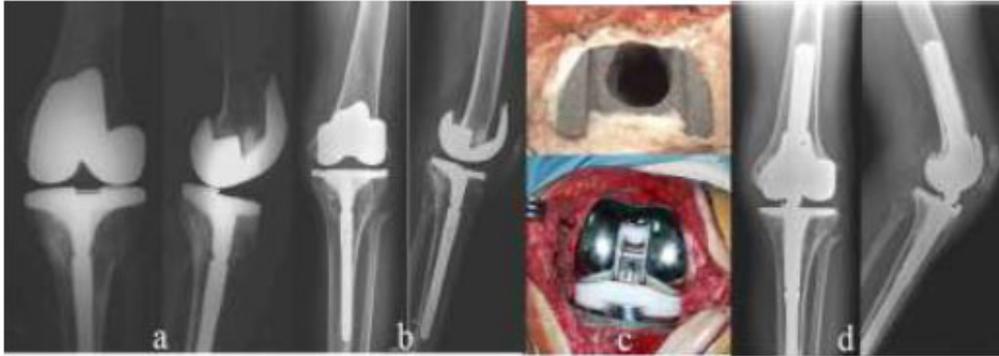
Radiologic history of the case presented in Fig. (2). Primary TKA in a 42 years-old haemophilic patient with high-titre inhibitors (a) . Four years after TKA, aseptic loosening with mechanical failure of the femoral component and in the posterior aspect of the tibial baseplate induced by recurrent bleedings (b) . The availability of a modern modular knee system allowed the revision with the use of a “cone” in the femoral side to fulfil the severe bone loss, and a high constraint ensured a stability of the implant (c) . Radiographic aspect 4 years after revision (d) .
